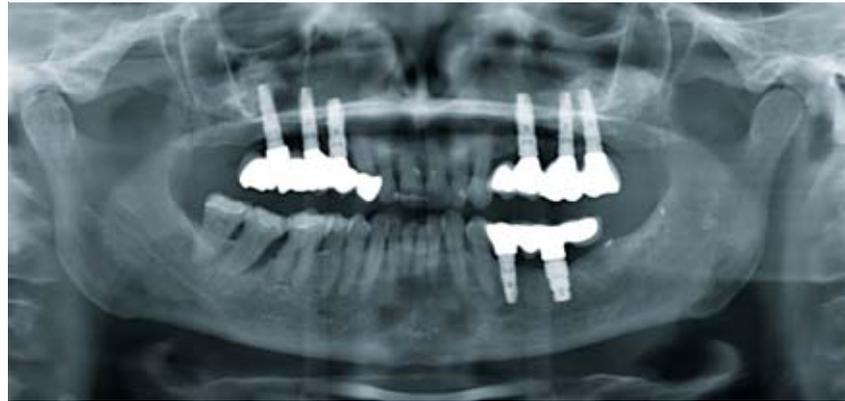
Orthopantomogram (initial condition).
